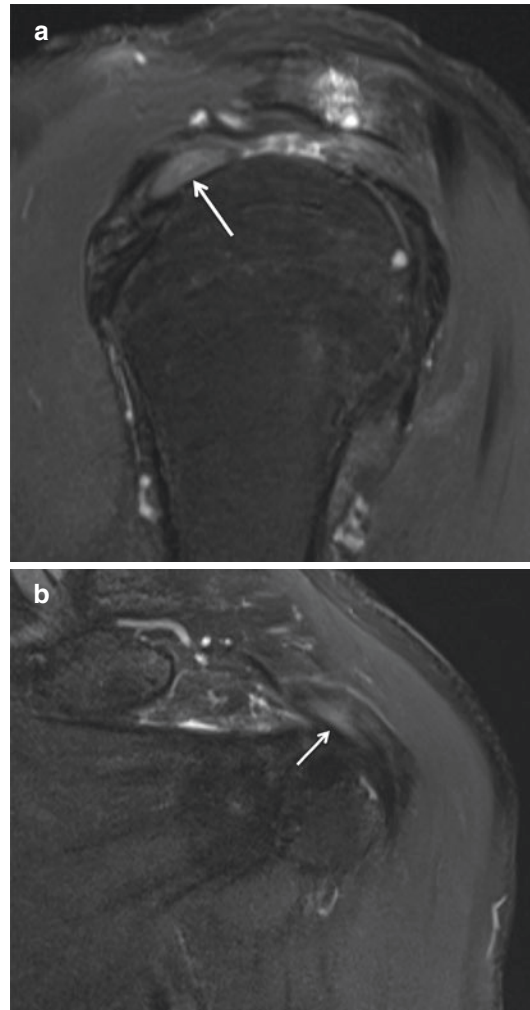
Hourglass biceps morphology. (a) Sagittal and (b) coronal fat-saturated T2 MR images demonstrate severe tendinosis of intra-articular biceps tendon with marked thickening and increased signal at entry into bicipital groove resulting in an hourglass morphology (arrows), which can be associated with impingement of the tendon
